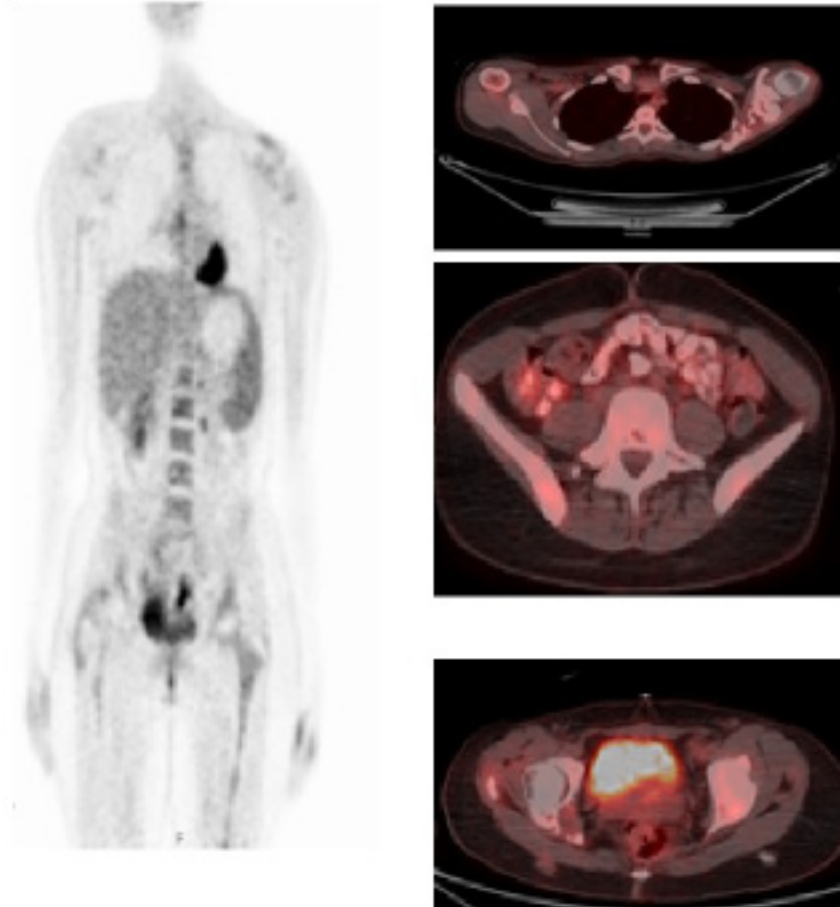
PET-CT scan (April 2018)
